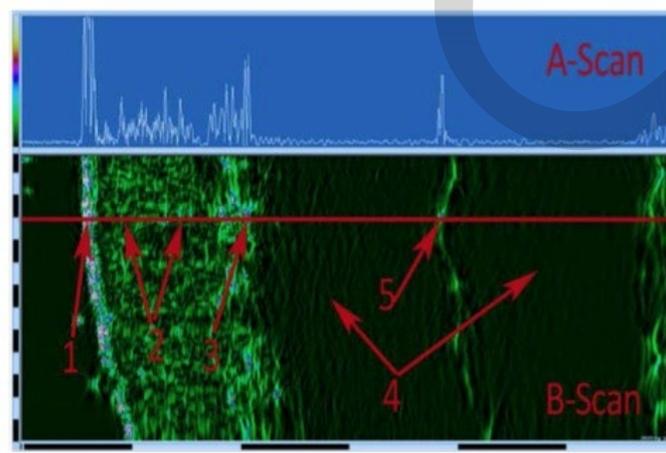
The structure of the skin during ultrasound scanning: 1: Epidermis; 2: Derma; 3: Border of the dermis and hypodermis; 4: Hypodermis; 5: Fascial, connective tissue in the hypodermis.
